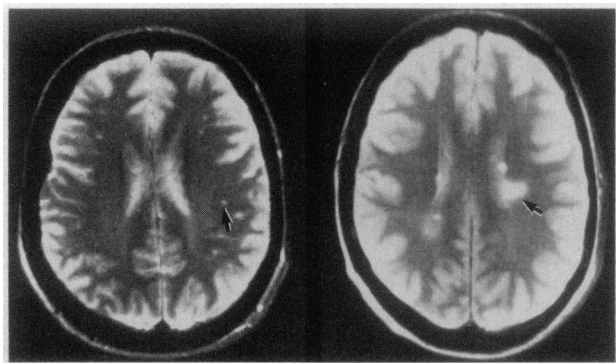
Magnetic Resonance Imaging Scans of the Brain of a 34-Year-Old Woman with Encephalopathy (Left Panel) and a 40-Year-Old Man with Leukoencephalitis (Right Panel).
